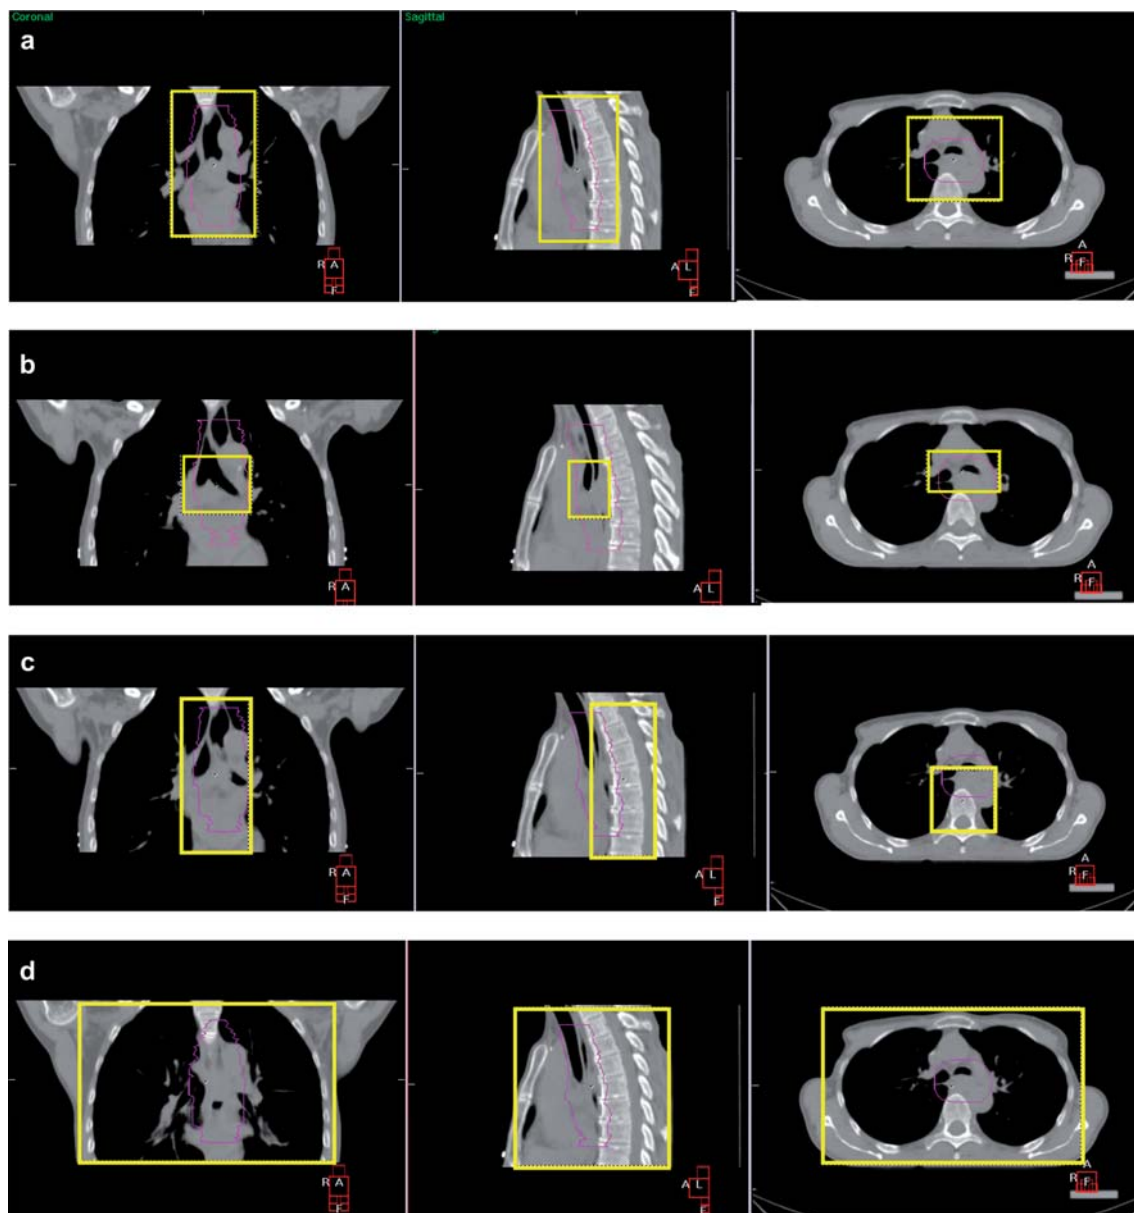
CT and CBCT overlay in coronal and transverse and sagittal plane. The area defined in yellow represents C-PTV (a), C-carina (b), C-vertebrae (c) and C-thorax (d) clipbox definition.
